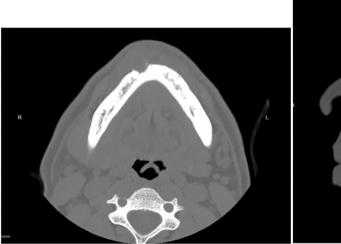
CT images. Axial and sagittal view of the gingival lesion demonstrated erosion of the alveolar bone but no invasion of the basal medullary bone.
